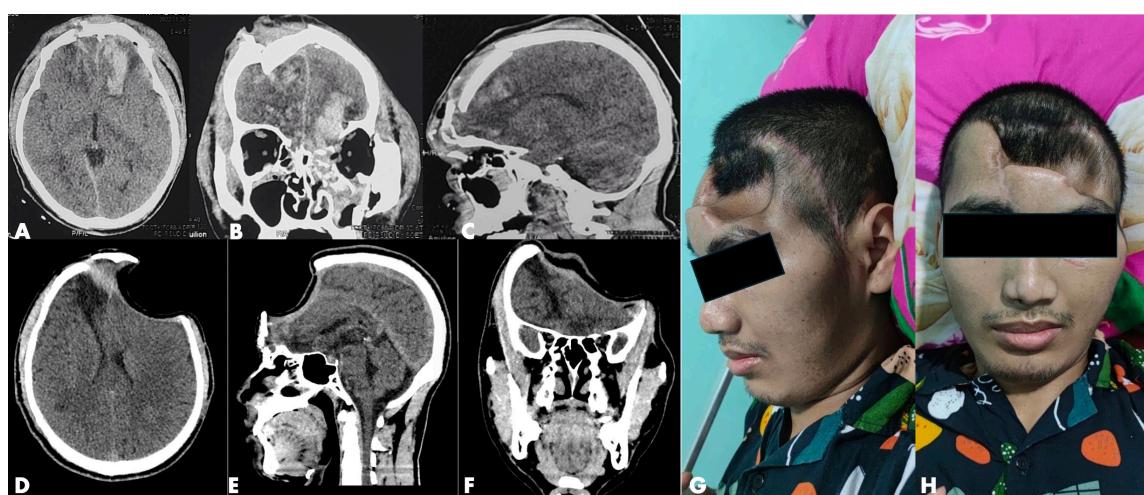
Preoperative CT revealed intracerebral haemorrhage and depressed fracture (A, B, and C). Radiological (D, E, and F) and clinical (G and H) images show features of the syndrome in the defect area after 3 months post-DC procedure.
